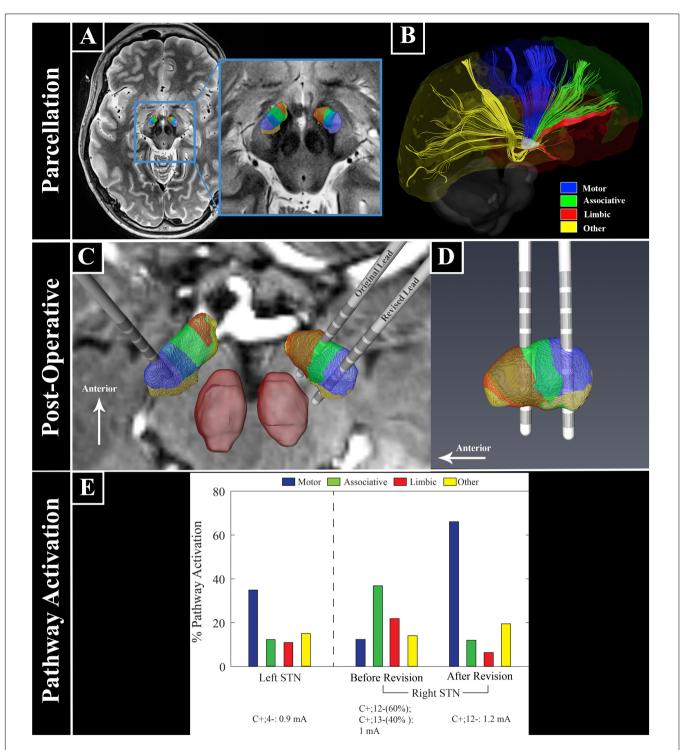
Ultra high field 7 Tesla MR images for patient-specific STN parcellation, lead location, and computational modeling. (A) STN parcellation results.
